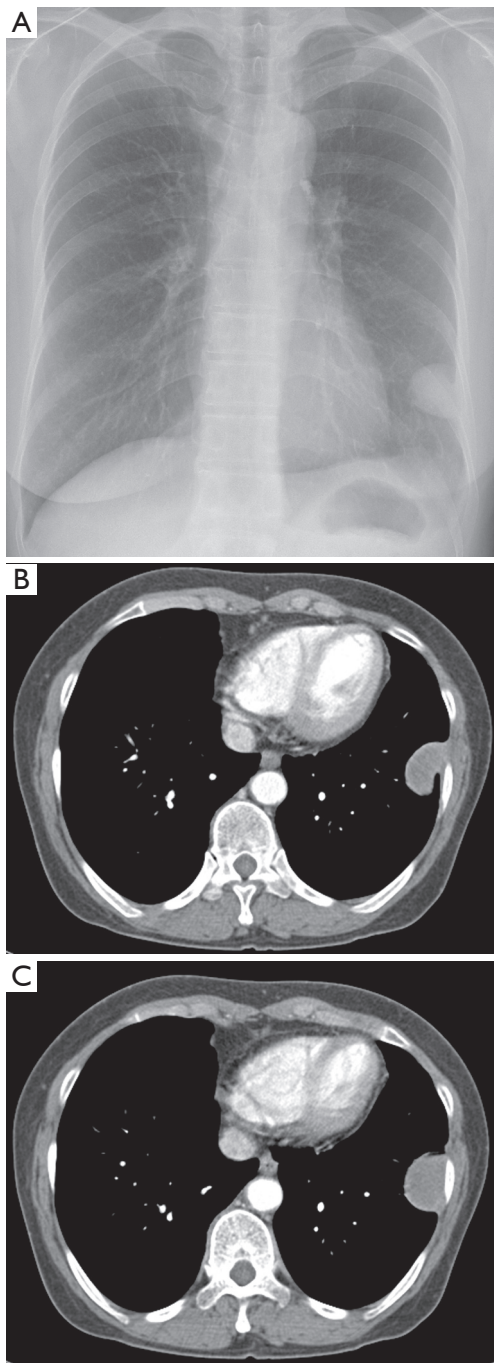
Initial chest X-ray and CT scan. (A) Chest X-ray shows a well-defined mass abutting the left lateral chest wall; (B,C) contrast-enhanced CT scan show a solitary sharp homogeneous oval enhancing mass abutting the pleura with diameter of 3.5 cm on the left lateral chest wall. The mass is pedunculated in the upper part of the left chest wall (B). Pleural effusion is not observed.
